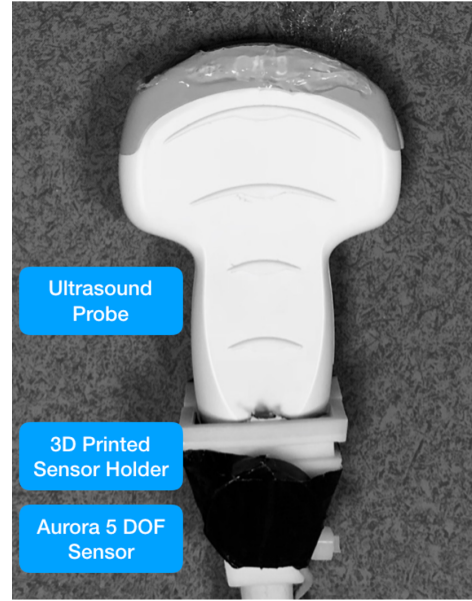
(b) A close-up of the ultrasound probe with an Aurora 6-DOF attached using a custom 3-D printed holder.
